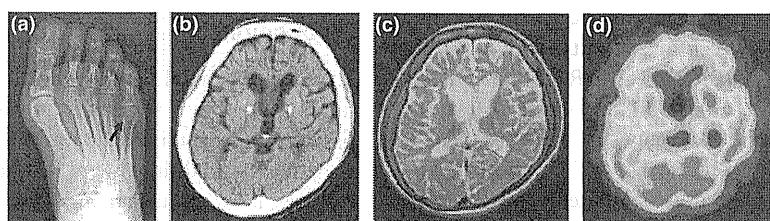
Neuroradiological features of the patient 3. (a) X-ray film. A cystic lesion in the fifth metatarsal bone (arrow). (b) Brain CT. High density lesions in the bilateral basal ganglia. (c) Brain MRI. Moderate atrophy of the frontotemporal cortex and marked dilatation of the lateral ventricle on an axial T2-weighted image (TR: 4500 ms, TE: 98 ms). (d) 99mTc-ECD SPECT. Moderate hypoperfusion in the frontotemporal cortex with preservation of the cerebral blood flow in the basal ganglia.
